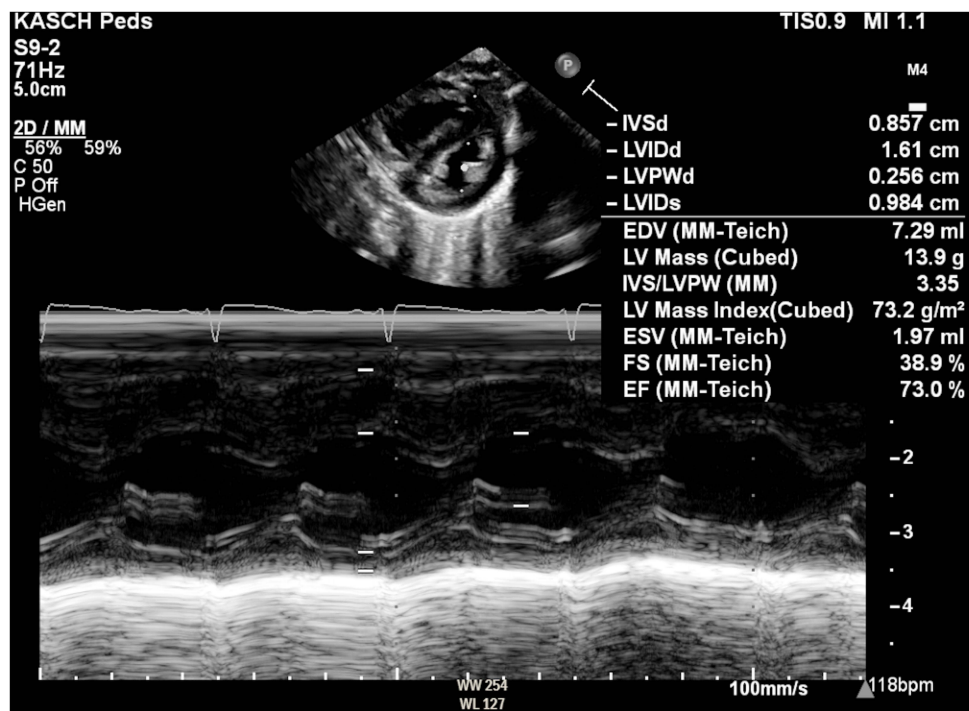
M-mode echocardiography showing normal left ventricular function.
